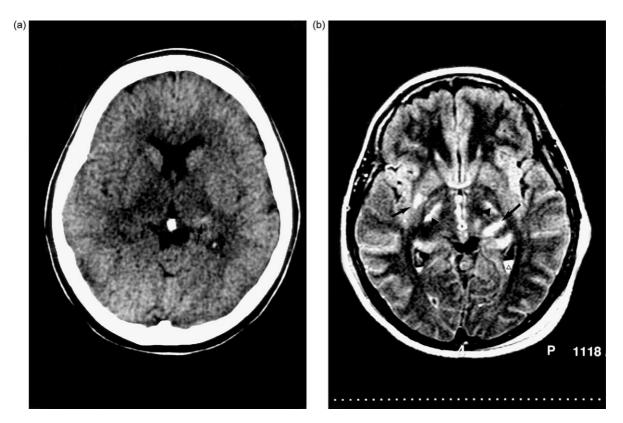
Male 19-year-old with severe closed head injury. (a) CT scan in the axial plane 3 h after injury, discloses a small hemorrhagic lesion in the left thalamus (arrow). (b) MR imaging FLAIR sequence in the transverse plane performed immediadely after the CT, demonstrates the thalamic lesion (arrow), and in addition edematous right SCGMI lesion (small arrow), DAI II in the posterior limb of the internal capsule bialeterally (arrowheads) and intraventricular hemorrhage in the occipital horns of the lateral ventricles (open arrowheads). The last is only retrospectively seen on CT.
